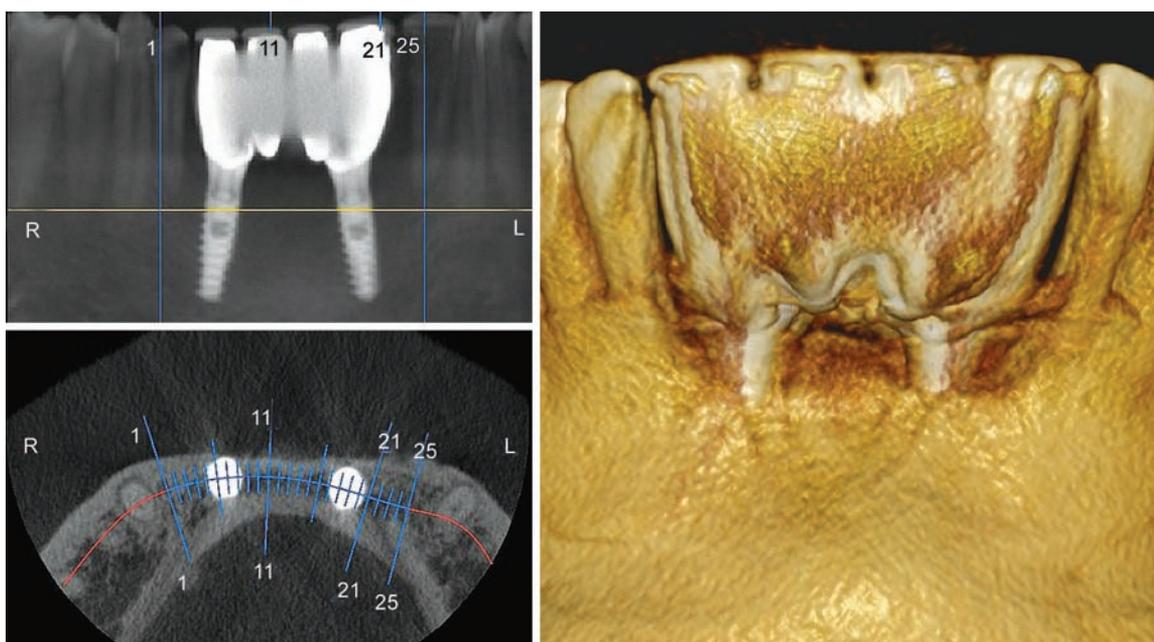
Radiographic examination using CBCT at 1-year follow-up postloading
